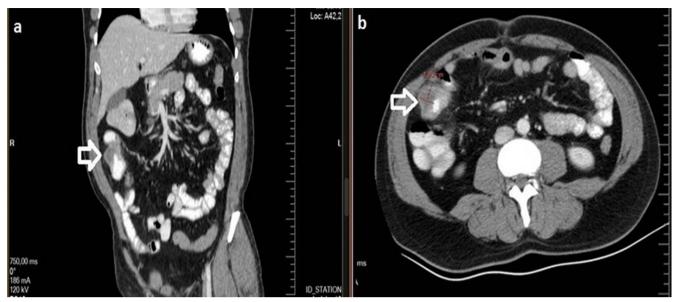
Axial and coronal images of abdominal computed tomography showing a significant wall thickening(18 mm) with highly suspicious malignant lesion at proximal part of ileum
